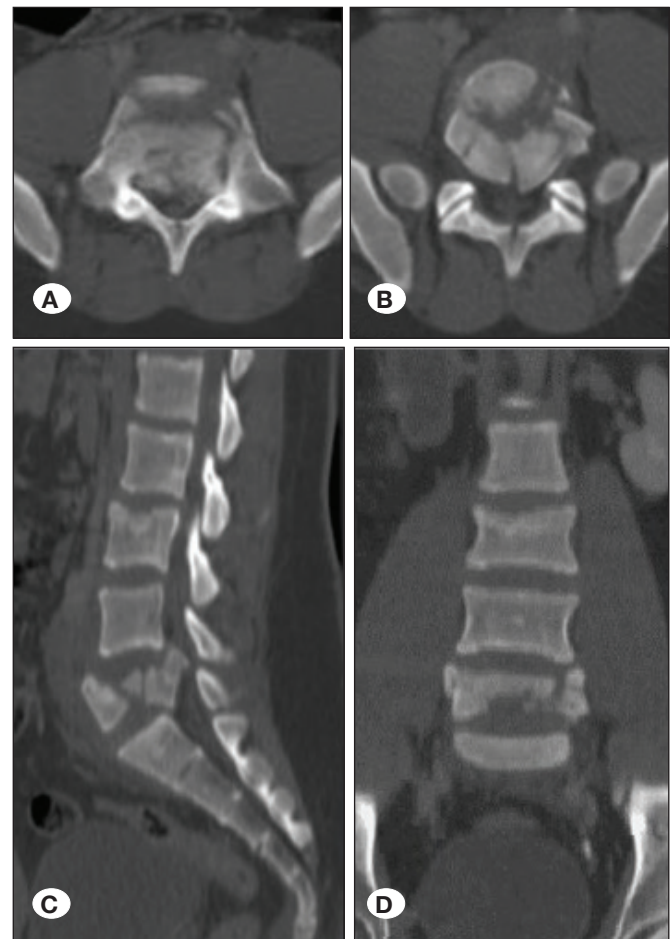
Case #6. A 20-year-old man with severe L₅ burst fracture after falling from a height. Preoperative axial (A), coronal (B), and sagittal (C) CT sections are shown.
